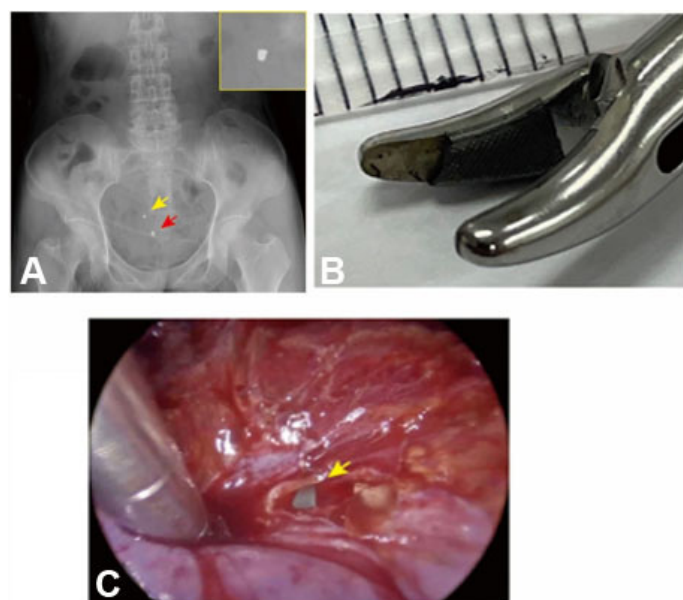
Intraoperative breakage of a laparoscopic needle holder confirmed by postoperative abdominal X-ray. (A) The yellow arrow indicates a radio-opaque shadow of approximately 3 mm in postoperative abdominal X-ray. The red arrow indicates the tip of urethral catheter. (B) Broken tissue-pad at the tip of laparoscopic needle holder. (C) Laparoscopic view of intraperitoneal retention of broken part (the yellow arrow).
